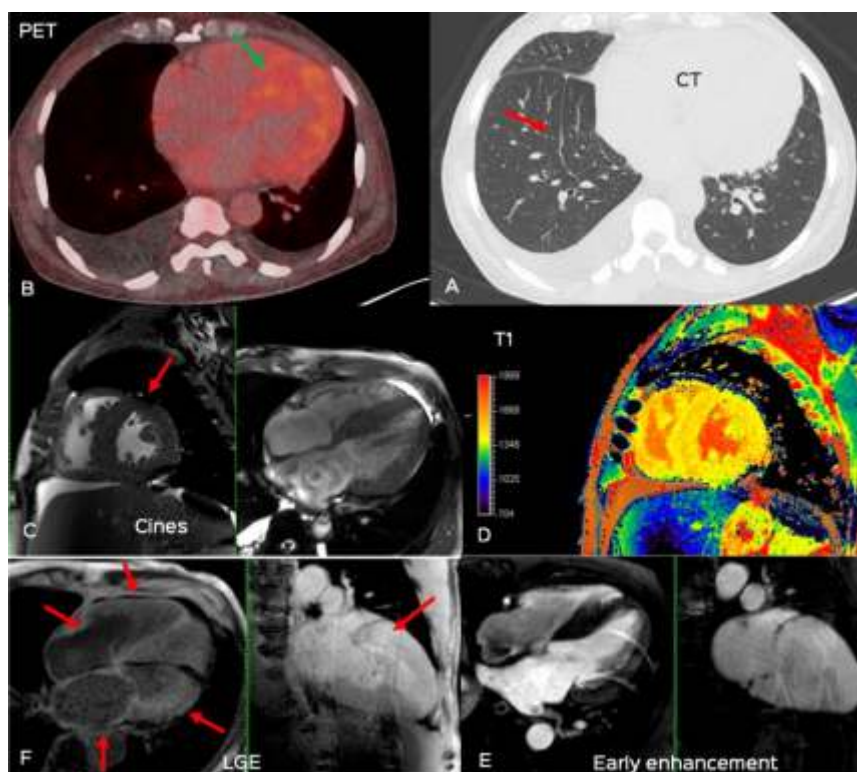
(A-F): 59-years old with fever. The lung window CT scan (A) shows septal thickening (arrow) and bilateral effusions, suggesting pulmonary edema. The PET/CT (B) shows thickening of the myocardium with increased uptake (green arrow), suggesting a myocardial pathology. There is also biatrial dilatation, suggesting a likely restrictive cardiomyopathy. The cine MRIs (C) show thickening (arrow) of the myocardium. The T1 image (D) shows increased T1 values (arrow). The early gadolinium (Gd) enhancement images (E) show deranged contrast kinetics, while the LGE (late Gd enhancement) images show diffuse enhancement (arrows) of the walls of all 4 chambers of the heart. These findings are characteristic of amyloidosis. (A video of the case is also available at <https://www.mricardiac.com/case44>)
